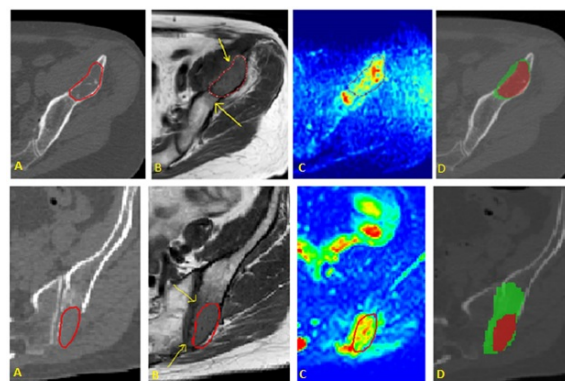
A: Delineations in CT, B: delineations in MRI (T1T2SE), C: delineations in DWI, D: difference in MRI (green) and CT (red) GTV delineations in lesion 1 and 2.
